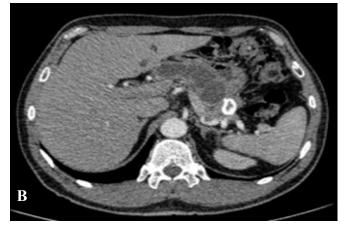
MD-IPMN: a — US image (DP — main pancreatic duct, arrows indicated papillary proliferations and extended parietal branch duct of the second order); b — MSCT image; c — MR image
